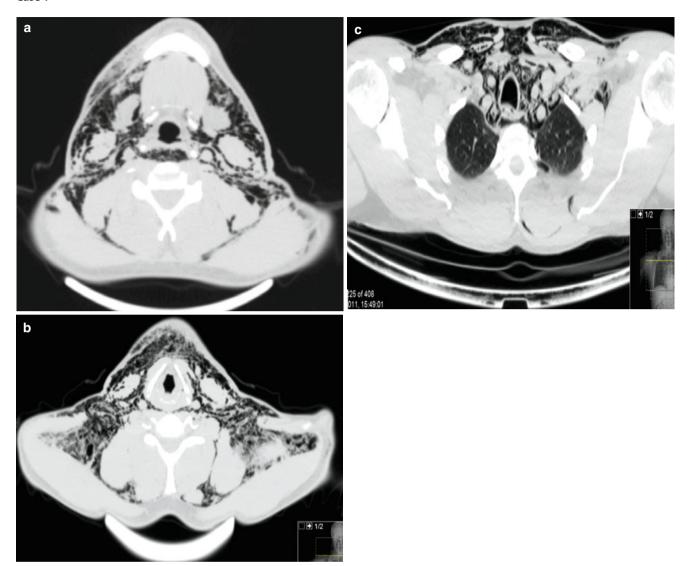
Further CT evaluation of the emphysema demonstrated its full extent (a-c). Treatment involved antibiotics and refraining from further nose blowing
